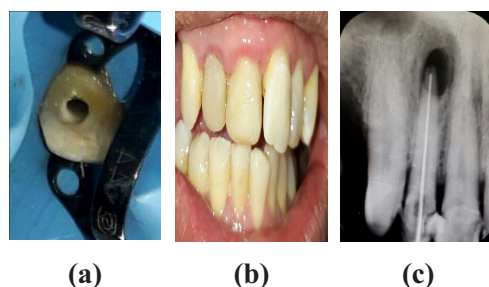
(a) Access cavity of tooth 12. (b) Adjusted proximal contact and distal artificial wall build-up of tooth 12, (c) Radiograph showing verification of working length with initial file
